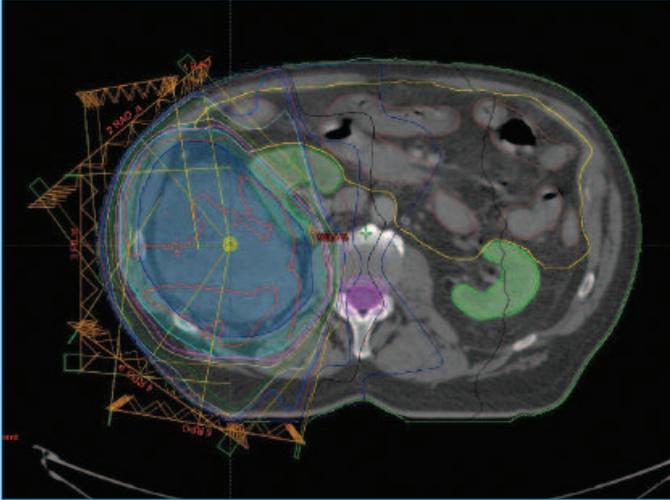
Panel B : A radiotherapy planning CT scan demonstrating the preoperative radiotherapy fields defined by Intensity Modulated Radiotherapy (IMRT) as part of the STRASS clinical trial. (The patient was randomised to receive preoperative radiotherapy).
